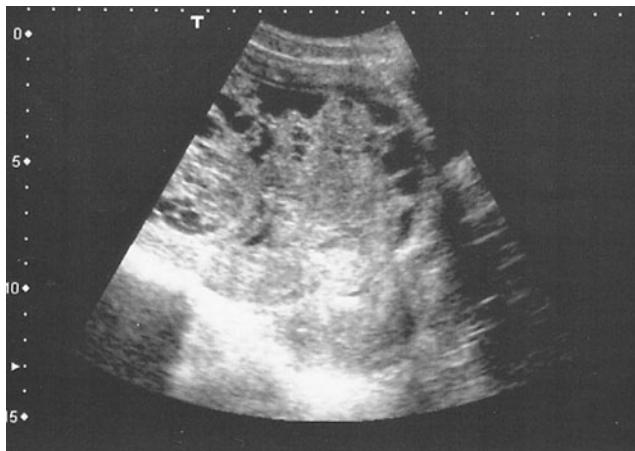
Ultrasound image of the large pelvic mass with heterogeneous echotexture containing part solid and part cystic components
